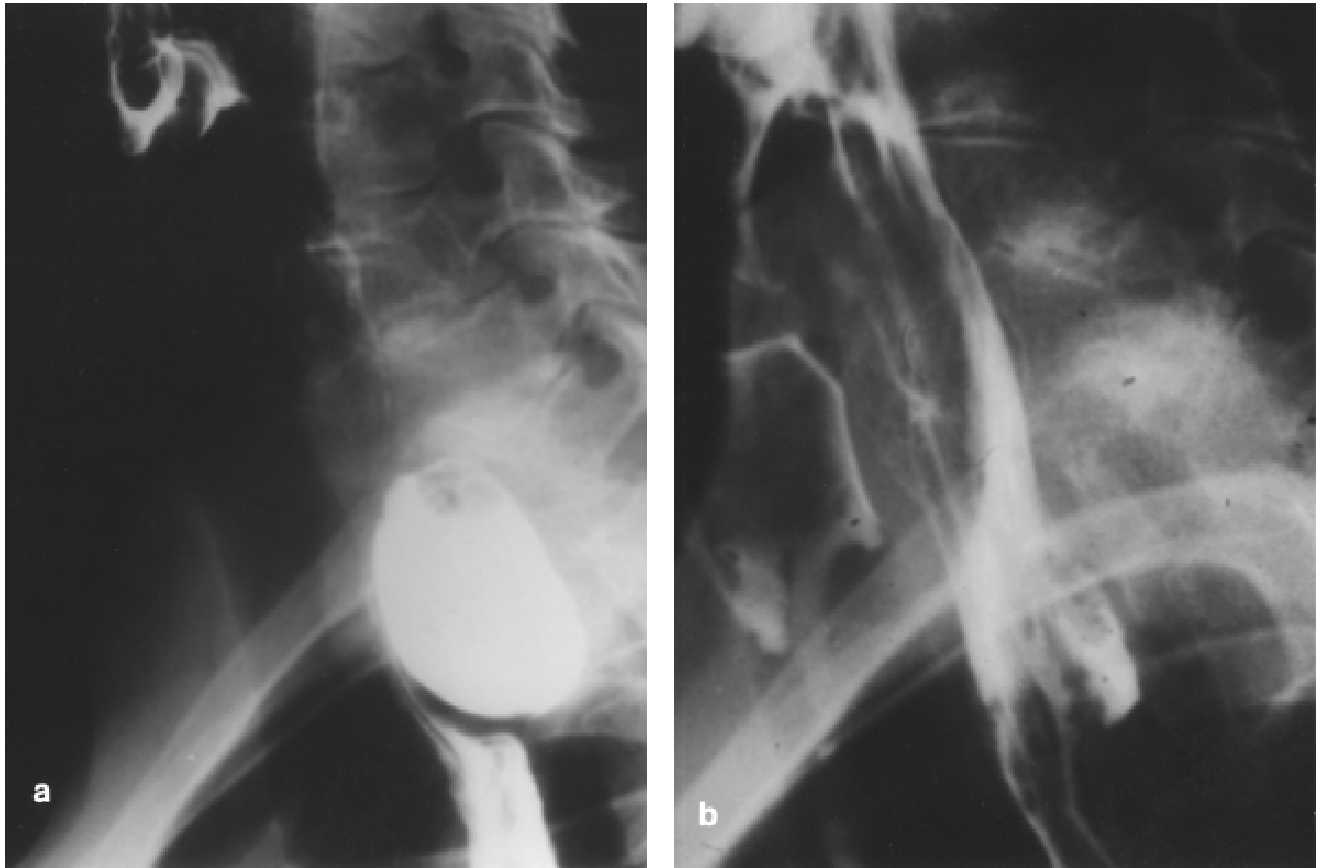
X-ray examination of hypopharynx and esophagus (a) before and (b) 1 year after endoscopic tissue bridge dissection with the CO₂ laser. There is no diverticulum detectable 1 year after surgery.
